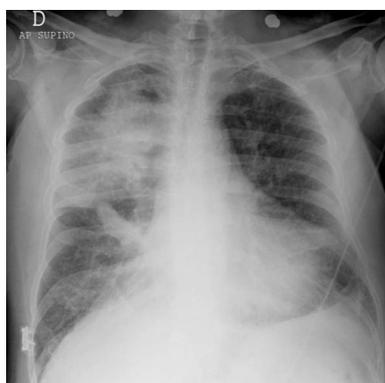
Antero-posterior chest radiograph with asymmetric pulmonary edema with grade 3 mitral insufficiency shows pulmonary edema predominantly within the right upper lobe.
